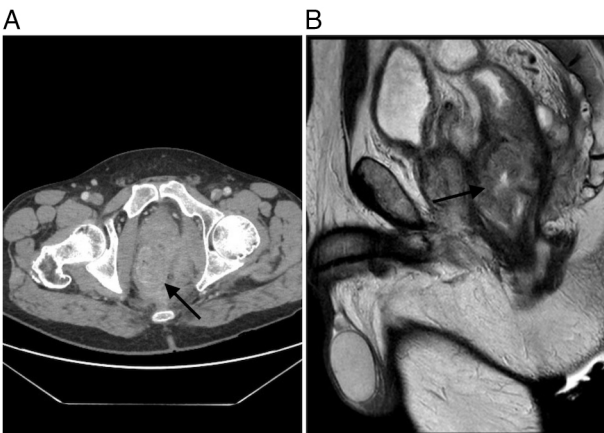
(A) CT scan and (B) MRI findings after radiotherapy treatment (the arrow indicates the tumoral mass).
